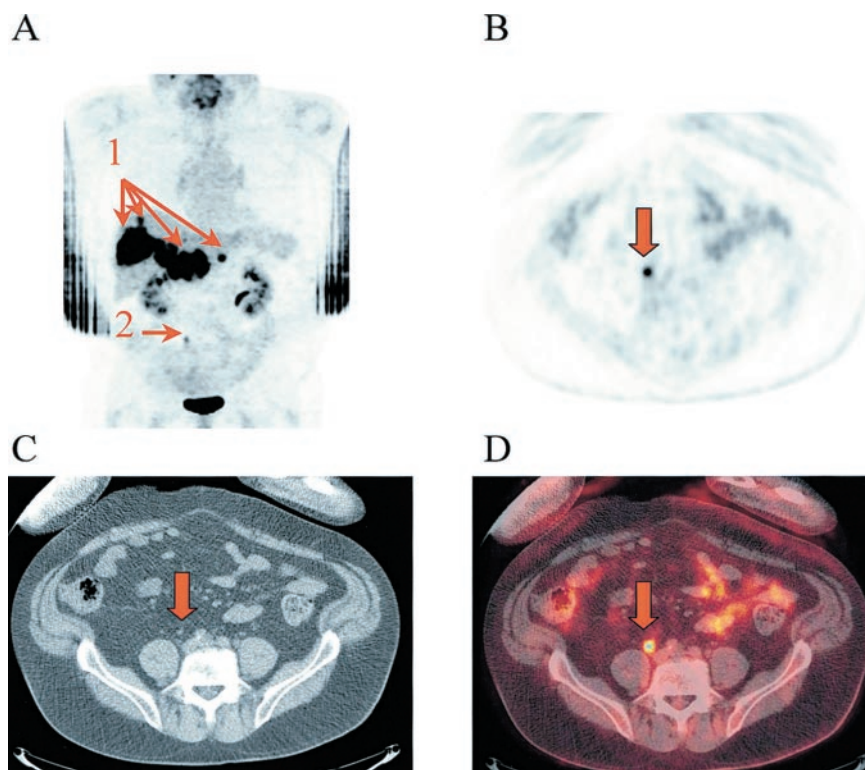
^{18}F -FDG PET images in anterior projection display (A) of patient with multiple liver metastases (1). For small focus of moderate metabolic activity (2) in right mid abdomen, equivocal diagnostic impression (score 2) was given because focus could represent benign activity (ureter) or malignancy (metastatic lymph node). Transverse PET images (B) at level of lesion 2 clearly showed that activity (arrow) on PET image corresponded to ureter on CT image (C) and fused image (D). Lesion characterization was thus improved to definitely benign (score 0) with PET/CT.
